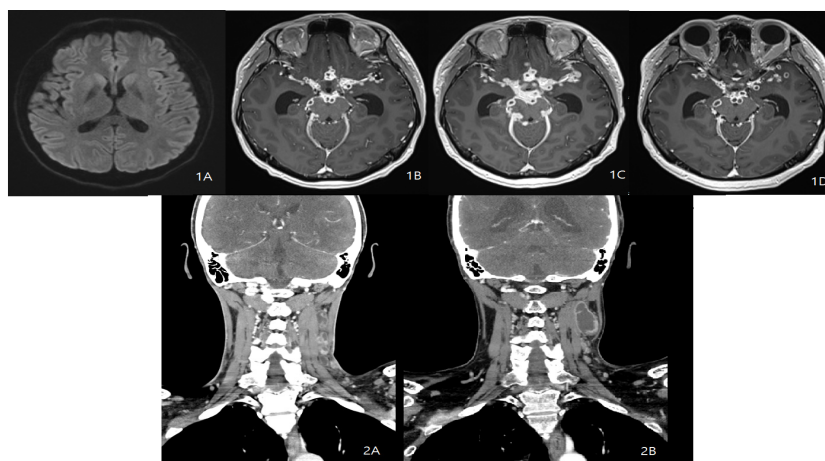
The serial Brain MRI Diffusion (1A) and Cranial Nerve (CE) (1B, 1C, 1D) on Admission day (1A), and after 3 months (1B), after 4 months (1C), and after 6 months (1D). 1D showed dramatic decrease of TB lesion of Brain, after thalidomide, and steroid were added.
